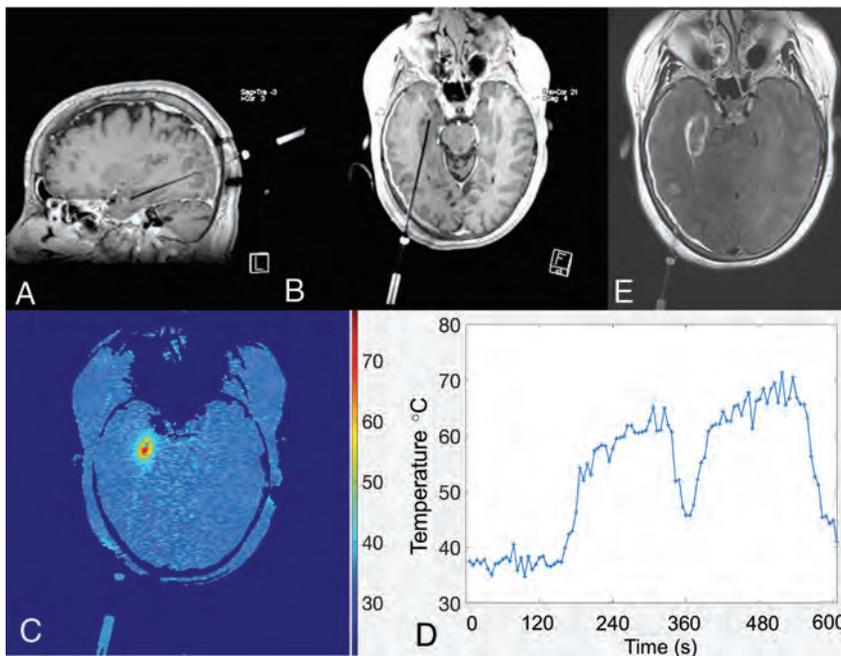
Real-time temperature mapping using phase-based PRF thermometry during stereotactic laser amygdalohippocampectomy for mesial temporal lobe epilepsy. Multiplanar spoiled gradient T1-weighted images obtained with intravenous gadolinium (A and B) demonstrate a stereotactically introduced, right-posterior-approach ablative probe, terminating within the right hippocampal formation. A parametric thermal map with inset scale and a temperature-time course graph (C and D, respectively) demonstrate that the estimated, relative temperature change from baseline following ablation exceeded 30°C. Contrast-enhanced T2-FLAIR axial image (E) through the treatment bed confirms the final zone of ablative injury.
